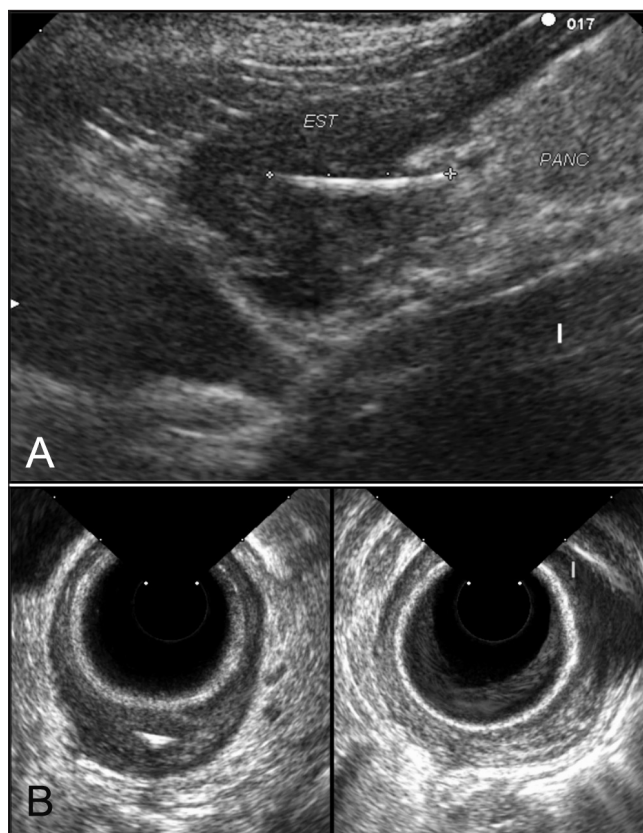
A. Abdominal ultrasound: Linear foreign body extending between the gastric antrum wall and the pancreatic head. B. Endoscopic ultrasound: Transversal and longitudinal view of the foreign body.
